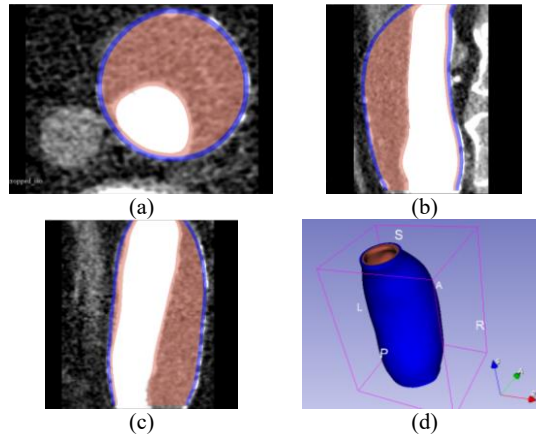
Patient-specific abdominal aortic aneurysm (AAA) geometry segmented from computed tomography angiography (CTA) using 3D Slicer. The segmented aneurysm wall with constant thickness of 1.5 mm is shown in blue and the segmented intraluminal thrombus (ILT) is shown in red; (a) a slice from the axial view of AAA, (b) a slice from the sagittal view of AAA, (c) a slice from the coronal view of AAA, and (d) the 3D rendered AAA.
